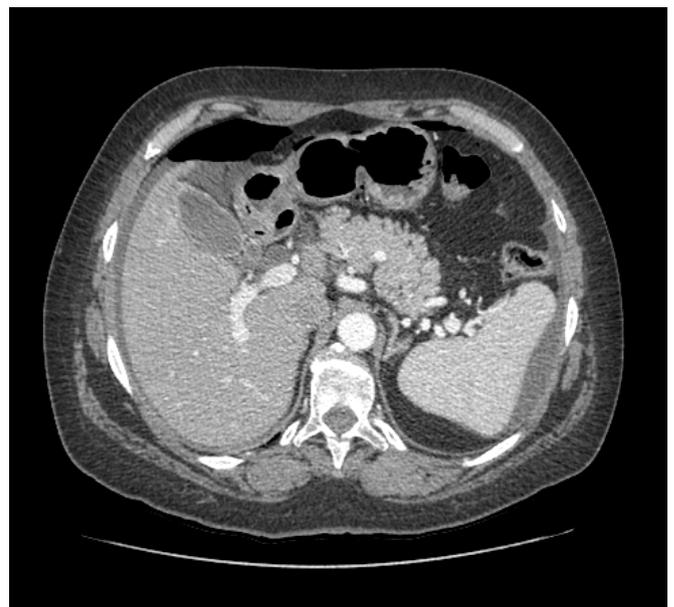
Generalised pneumoperitoneum in contrast-enhanced abdominal CT.
